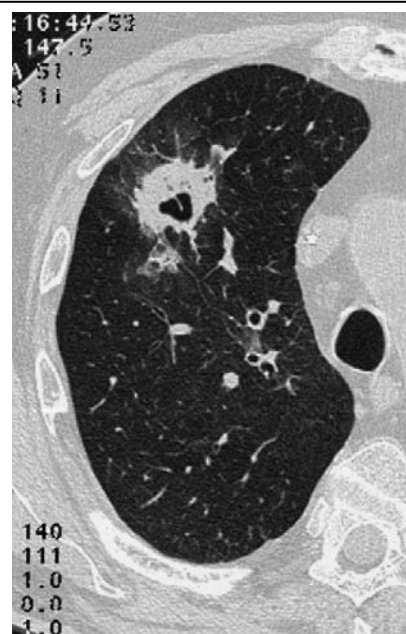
CT-scan in a patient with absolute neutrophil count $< 0.1 \times 10^9/L$: lung aspergillosis.
